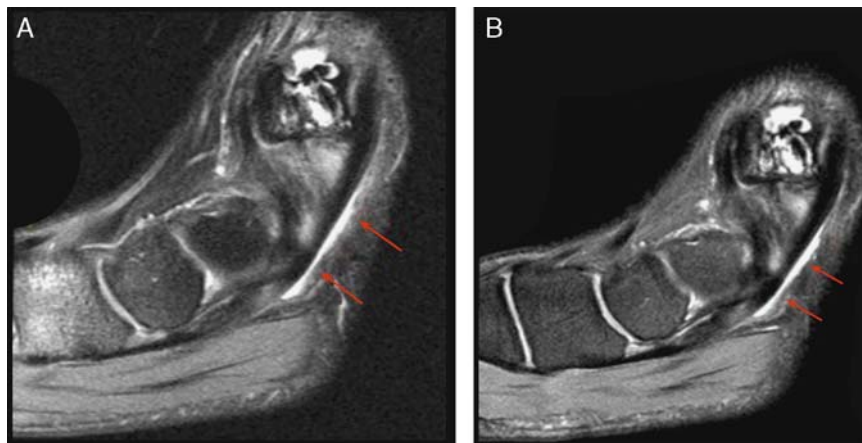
A, Case of posterior tibial tendinosis before PRP therapy. B, Same patient after PRP treatment. This patient had no resolution either clinically or on MRI at the 6-month time point. This patient has since gone on to posterior tibialis tendon reconstruction. Arrows indicate pathology. PRP indicates platelet-rich plasma.
